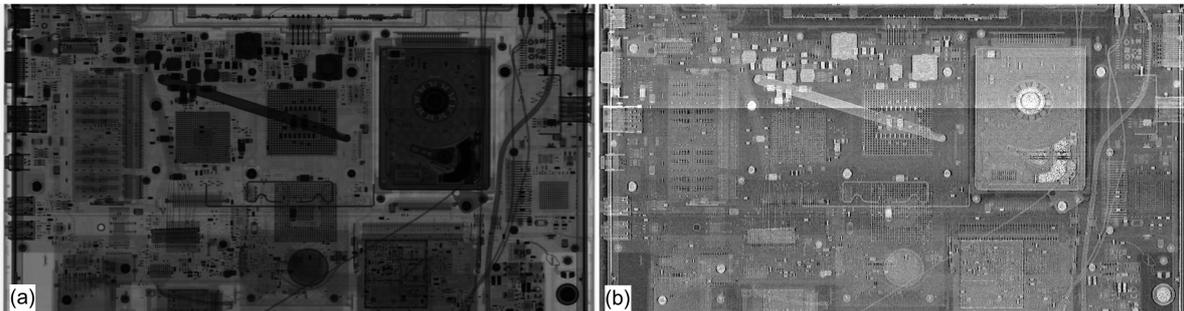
attenuation (a) and dark field (b) images of a whole laptop obtained at 100 kVp with the large area, high x-ray energy scanner described in ref. [41].
